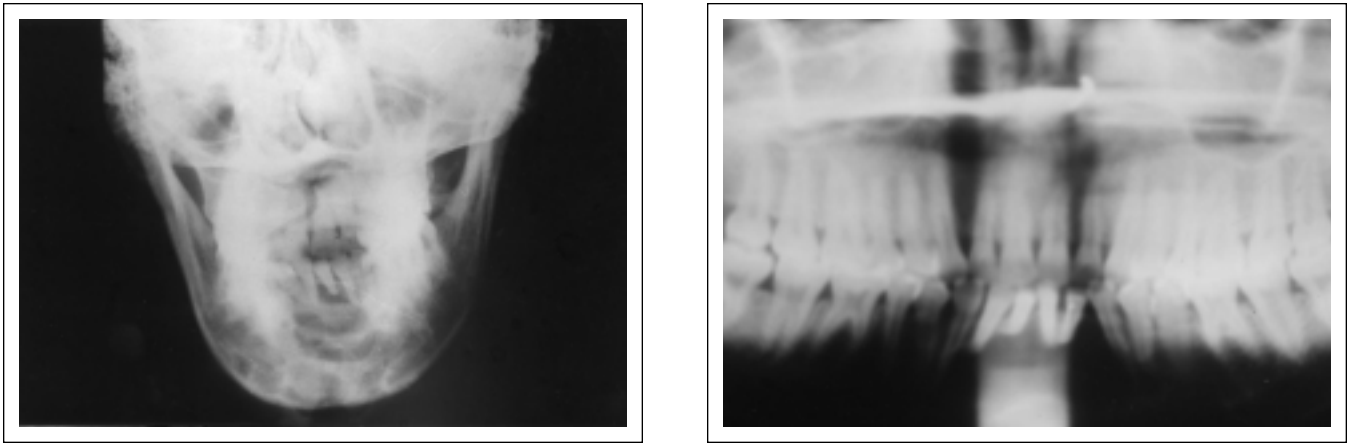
Pre treatment radiographs (A) PA view of mandible, (B) Panoramic view showing large well-circumscribed radiolucent lesion in the symphyseal area of the mandible. There is marked root resorption of lower incisors.
